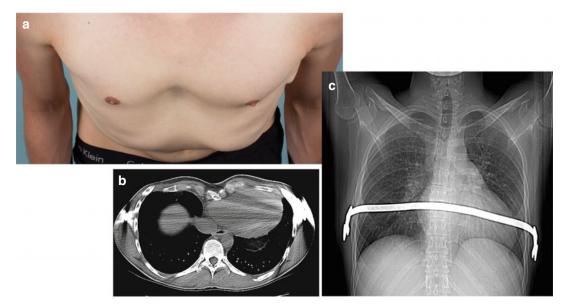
(a–c) Photographs (a) and radiographic imaging (b, c) are shown of a 26 year-old male with pectus excavatum deformity 2 years after placement of single
